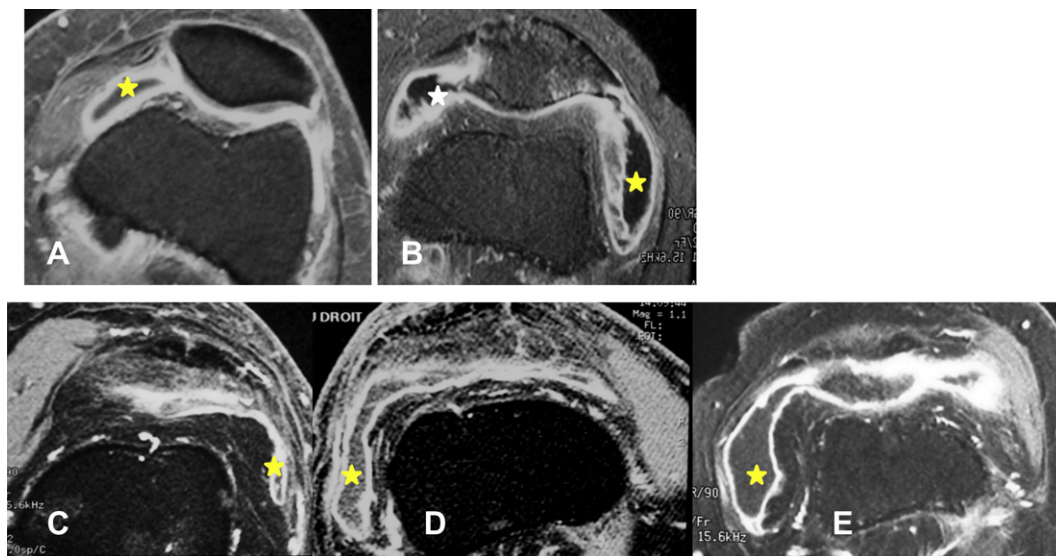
MRI-effusion score is obtained from axial T1-injected images. On this sequence effusion appeared as a low signal. In the middle part of the patella lateral and medial gutters were graded on a four-point scale: A: grade 1 in the medial gutter and 0 in the lateral recess; B: effusion in graded 2 in the medial recess and 3 in the lateral recess. On the suprapatellar recess, just above the patella, the effusion (yellow star) is graded on axial injected sequence grade 1, 2 and 3 on figure C, D and E respectively.
